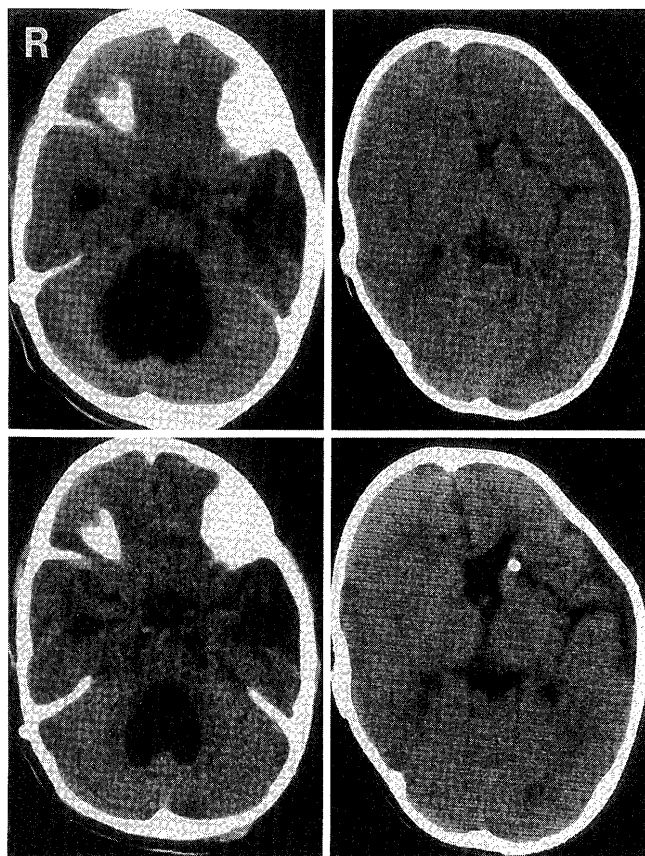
Preoperative (upper row) and postoperative (lower row) computed tomography scans showing the fourth ventricle was markedly reduced in size and slit-like ventricle was resolved 2 months after the operation. *left column: infratentorial, right column: supratentorial.*
